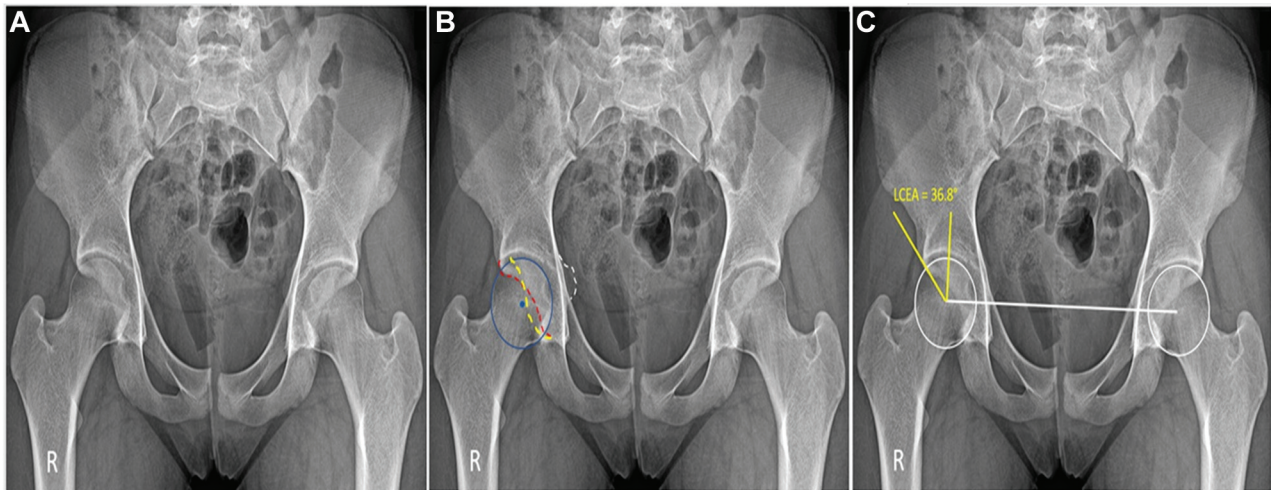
Radiographic assessment of acetabular retroversion in the supine anteroposterior pelvis view. All images correspond to the same patient. R, right hip. (A) Supine anteroposterior pelvis view. (B) Red dotted line, anterior acetabular wall; yellow dotted line, posterior acetabular wall. Intersection between the walls indicate a positive crossover sign. Blue dot, center of the femoral head lateral to the posterior wall (positive wall sign); white dotted line, positive ischial spine sign. (C) LCEA (lateral center-edge angle) was measured.
